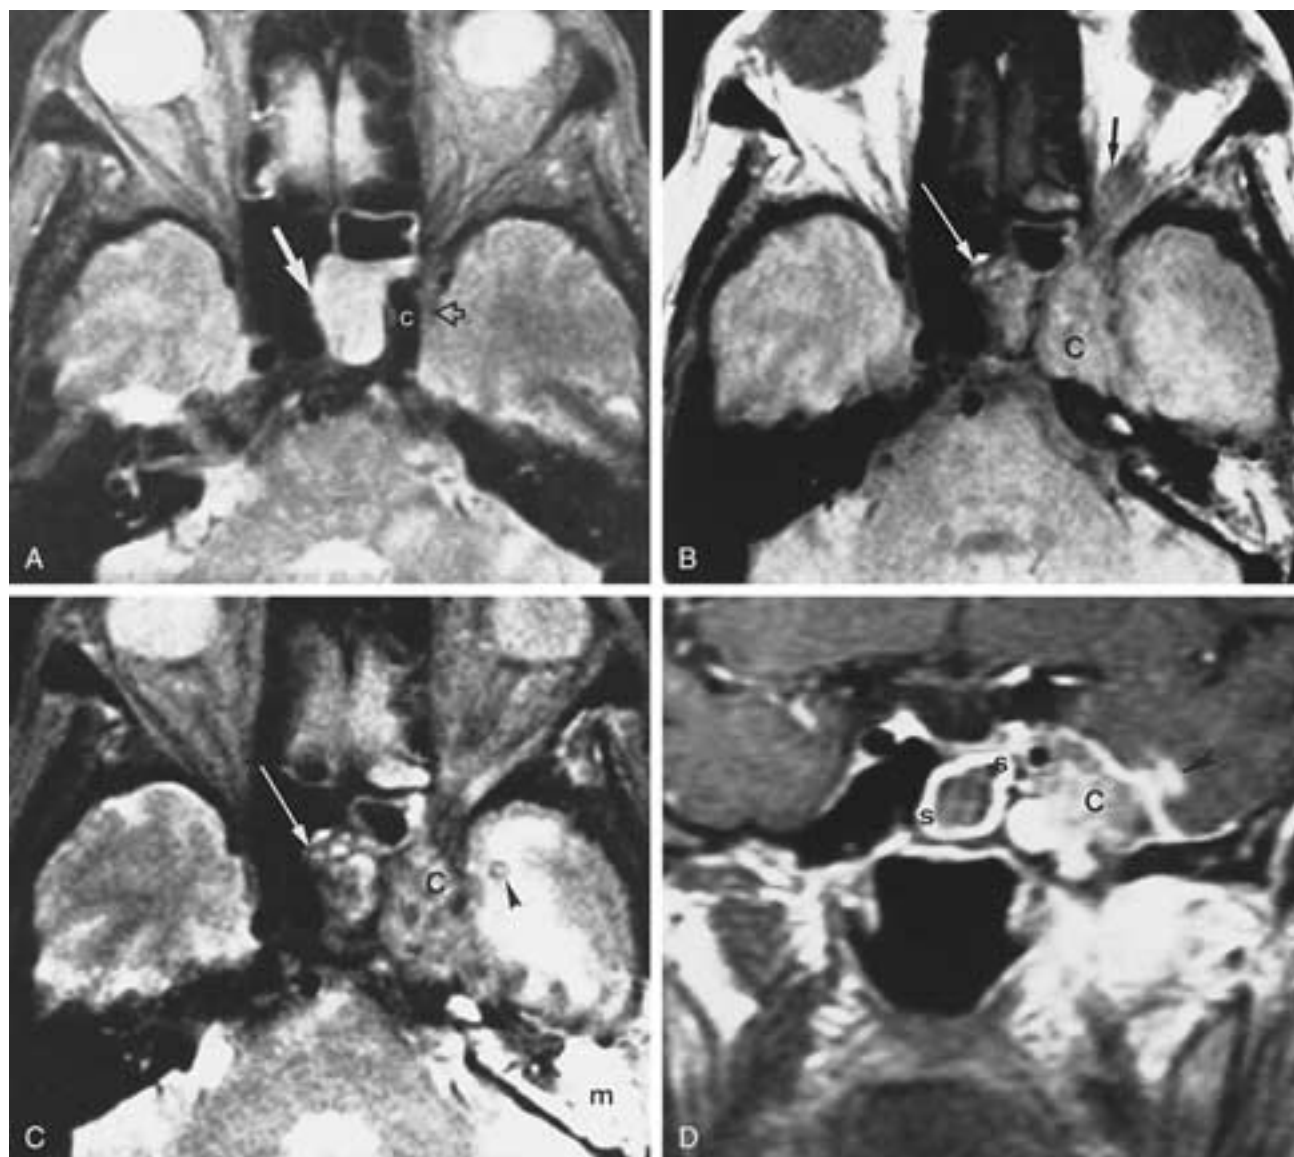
Aspergillosis. A, Axial T2-weighted MR image shows soft-tissue induration in the left sphenoid sinus (white arrow). Note the internal carotid (C) and early soft-tissue infiltration of the left cavernous sinus (hollow arrow). B, Axial PW MR image follow-up scan. C, Axial T2-weighted MR image follow-up scan. Scans show progression of the pathologic process, with marked infiltration of the left cavernous sinus (C) and formation of the left temporal lobe abscess (arrowhead) with marked peripheral edema. Note apical infiltration into the left orbit (black arrow in B) and inflammatory mycotic tissue in the left sphenoid sinus (white arrow). The mycotic process appears rather hypointense on the T2-weighted MR image, a not uncommon finding with fungal infections. Note the nonvisualization of the left internal carotid artery (compare with A); this results from invasion of the mycotic process, a finding confirmed by angiography and surgery. The mycotic process (m) has extended over the left petrous apex. D, Postcontrast (Gd-DTPA) coronal MR image shows enhancement of mucosal thickening of the left sphenoid sinus (S) and infiltrative process of the left cavernous sinus (C) and the temporal lobe abscess (arrowhead).
